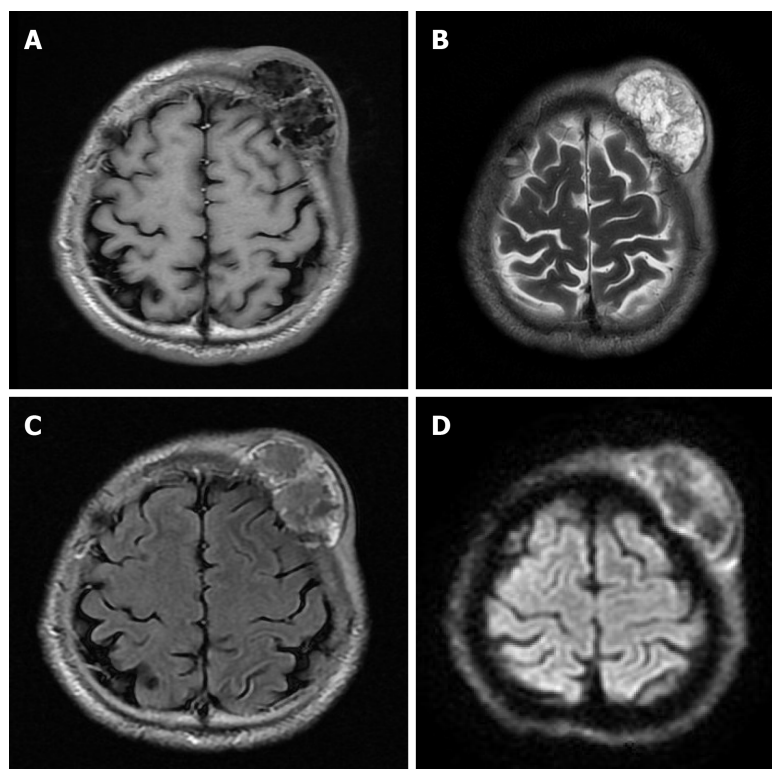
The magnetic resonance imaging revealed an irregular lesion, approximately 3.55 cm × 6.34 cm in size, in the left frontal region with clear boundaries and visible separation. The adjacent skull was damaged and the dura mater was involved. A: T1 showed complex signal with a dramatic low signal; B: T2 showed complex signal with a dramatic high signal; C: T2 FLAIR showed high marginal and low central signals; D: DWI showed high marginal and low central signals.
